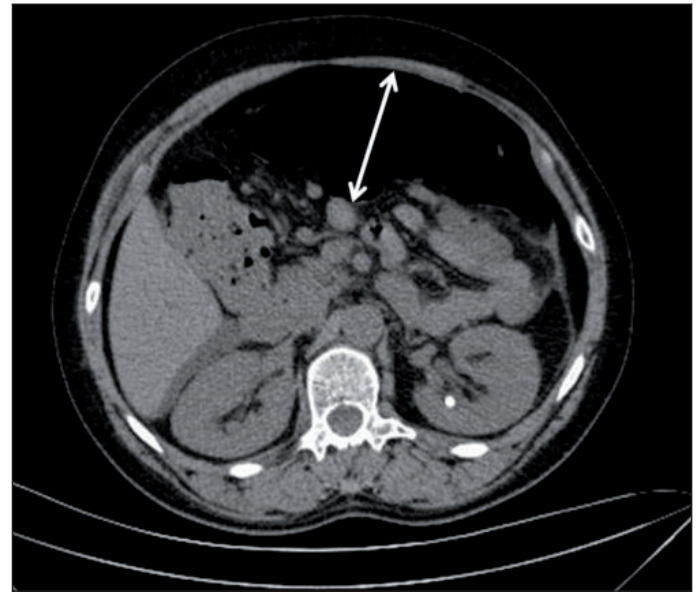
Computed tomography scan of the abdomen showing toxic megacolon.
